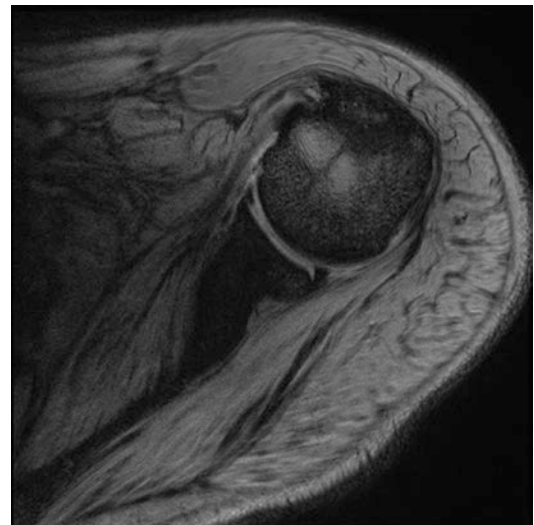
MRI of a left shoulder (axial view) with a partial-thickness articular-sided tear of the subscapularis tendon and an unstable long biceps tendon
